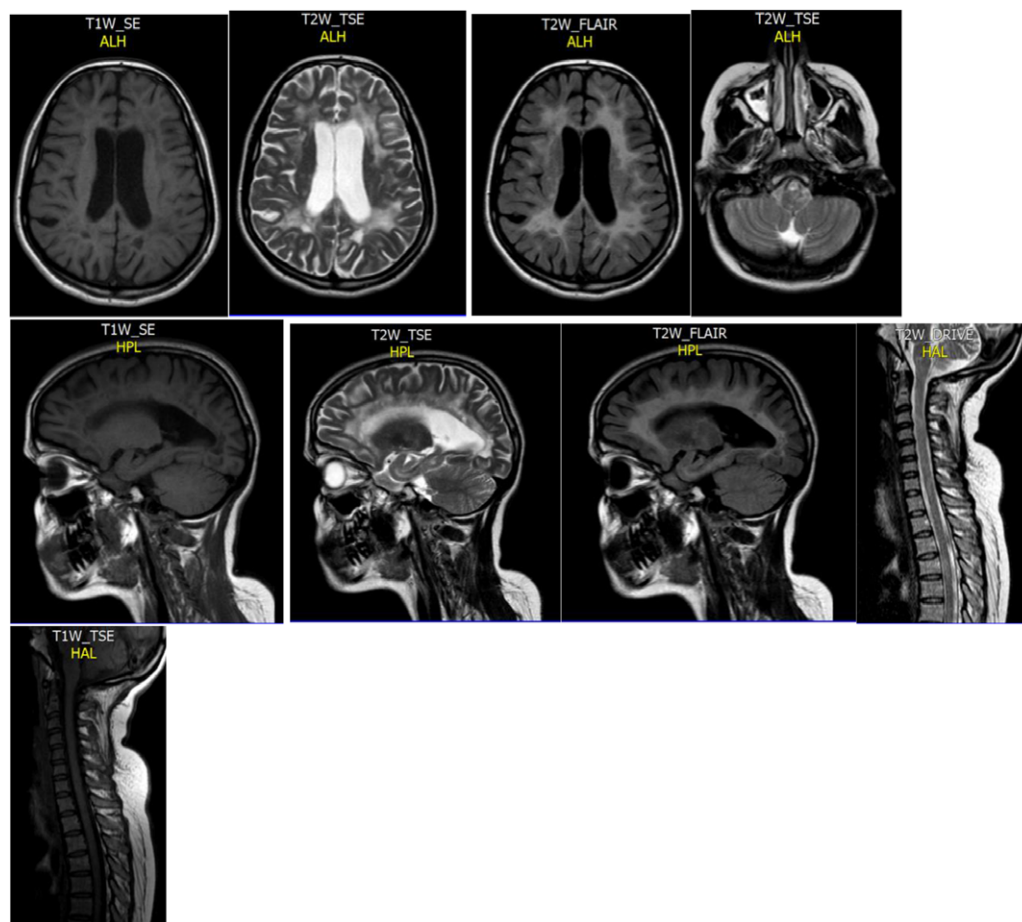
The brain and cervical spine MRI in May 2021 showed diffuse bilateral periventricular white matter hyperintensities on T2-weighted Imaging (T2WI) and Fluid-Attenuated Inversion Recovery (FLAIR) which were hypointense on T1-weighted Imaging (T1WI). There was a dilation of both the lateral and third ventricles, in addition to generalized atrophic changes. Regarding the sagittal cervical and upper dorsal spine MRI, the non-contrast T1WI showed normal cord size with no signal abnormality, while the T2WI image showed a heterogenous signal with multifocal intrinsic hyperintense lesions, more obviously opposite to C3–C4, C7–T1 and T4 levels.
